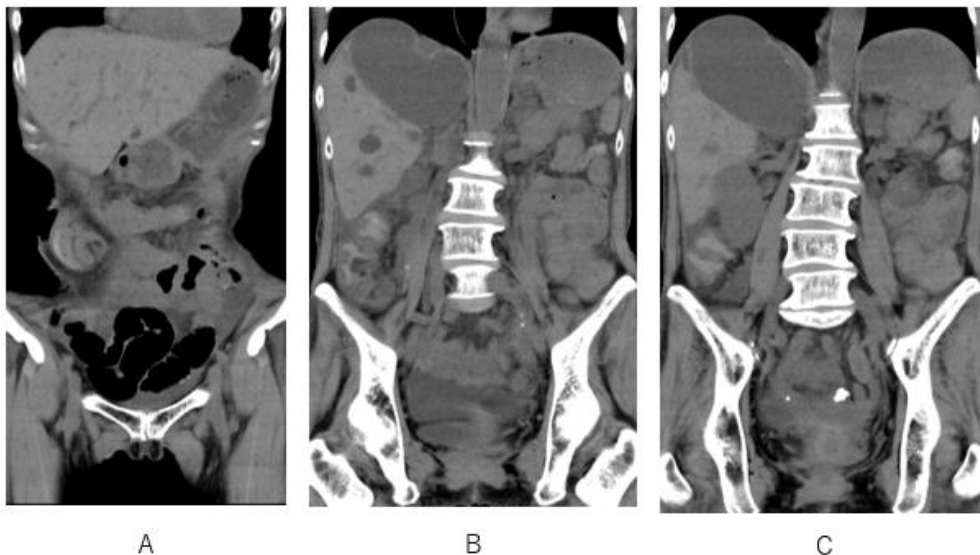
Fluids with high attenuation in cecum and ascending colon are depicted on coronal CT.
